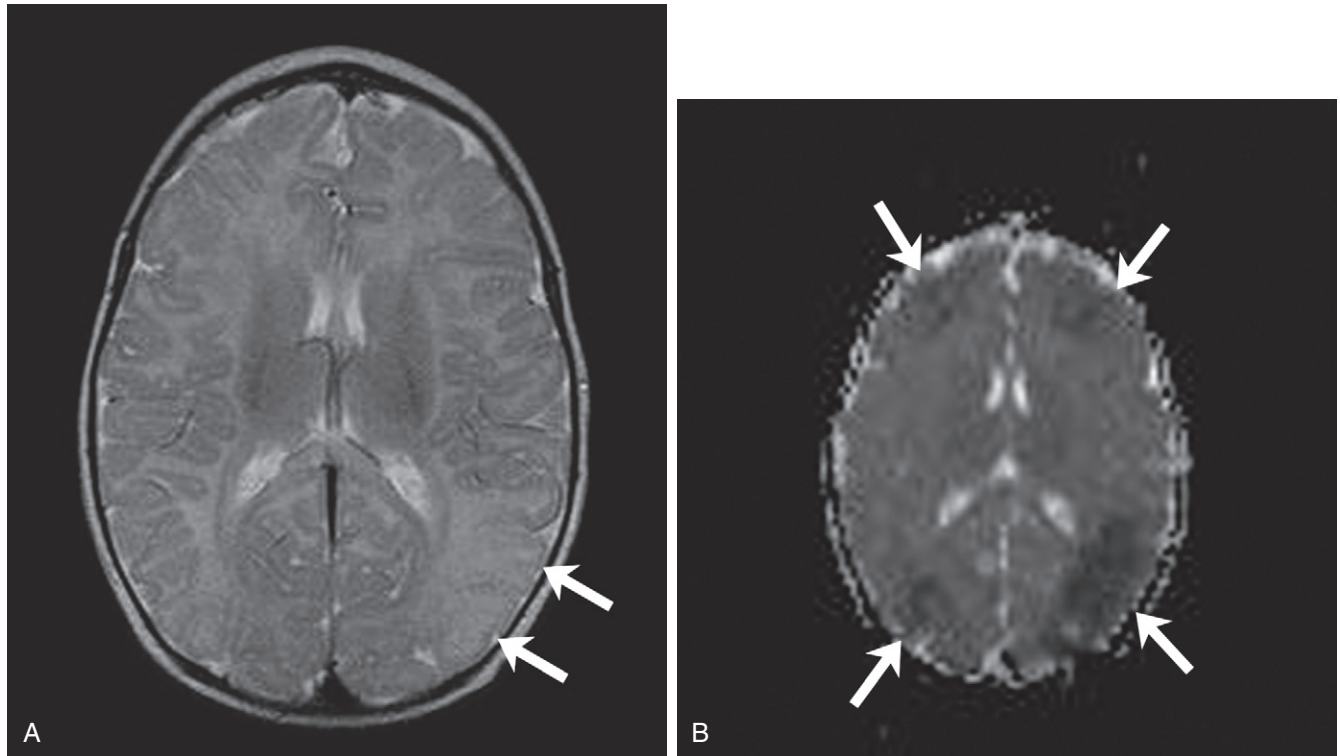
Watershed infarct. A, Axial T2-weighted MR image shows some loss of the gray-white interface on the left posteriorly (arrows). B, Diffusion-weighted image shows bilateral restricted diffusion consistent with ischemic injury in a watershed distribution (arrows).
